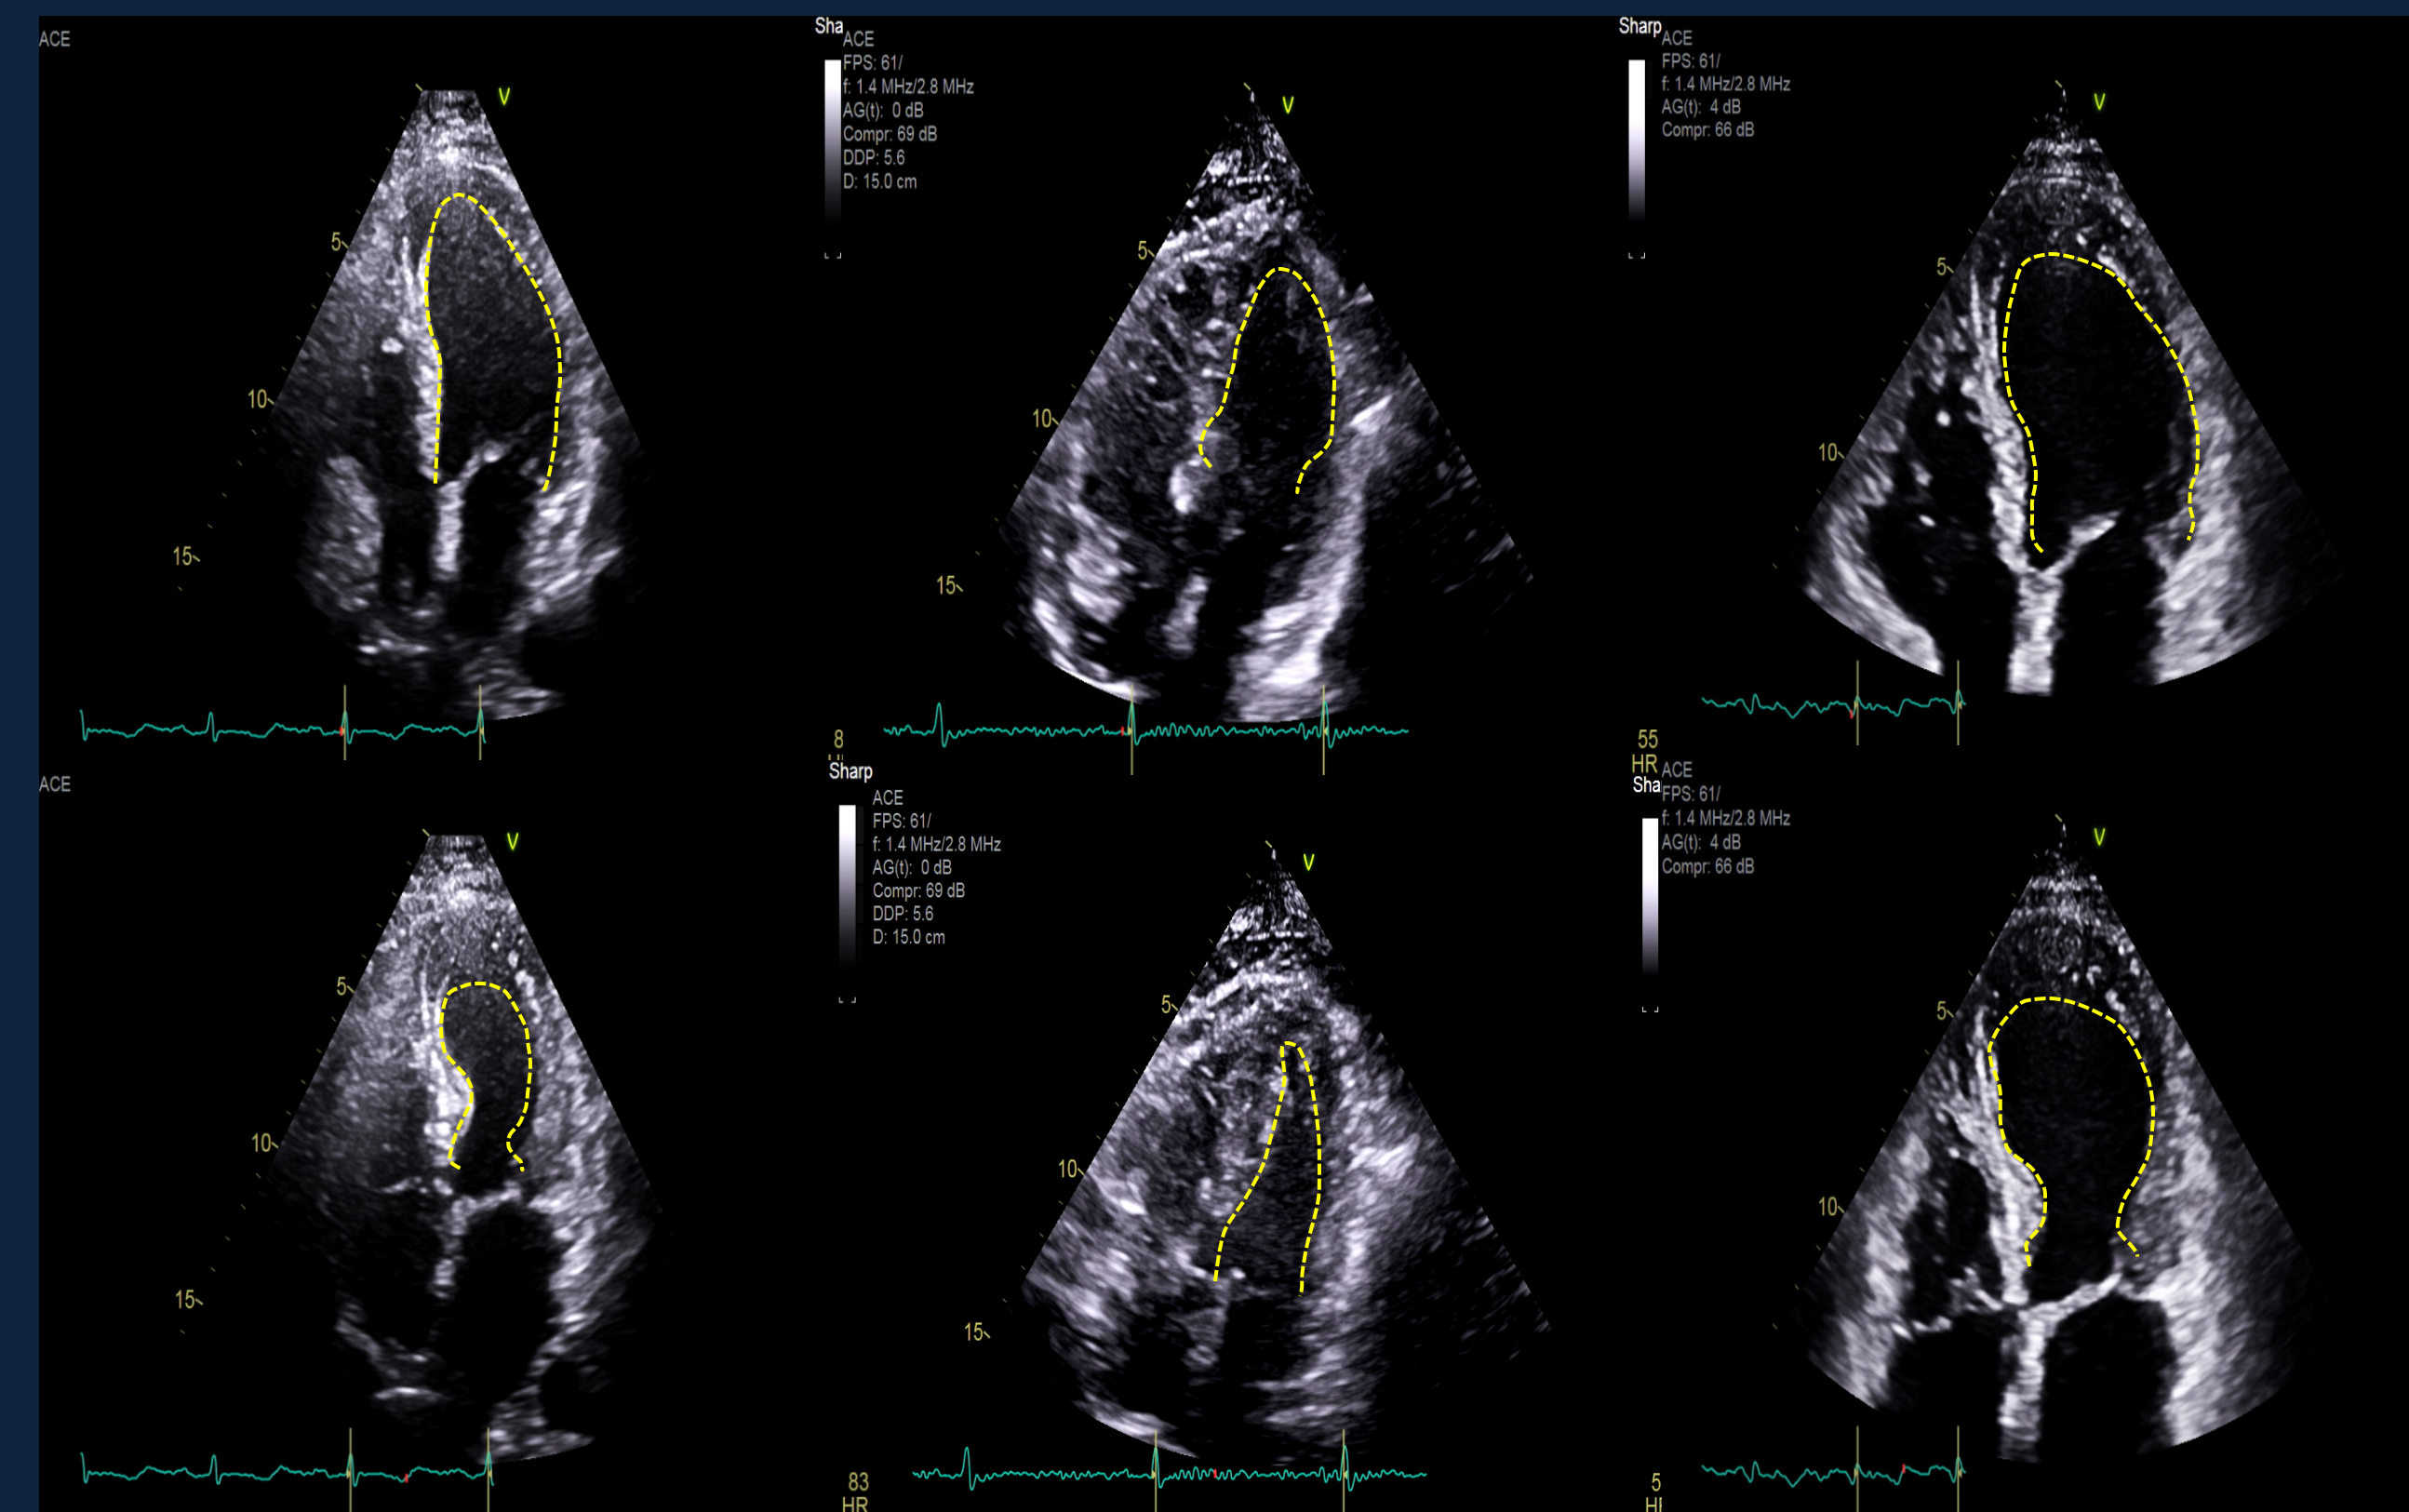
Transthoracic echocardiogram performed at initial presentation (A), at five month follow-up (B), and on readmission for recurrence of symptoms (C). Apical four-chamber in diastole (top row) and in systole (bottom row) demonstrating apical hypokinesis and basilar hyperkinesis on initial presentation (A) and again on readmission (C) with transient recovery and normalization of LV function between the hospitalizations (B). Endomyocardial border is outlined (yellow line) to help visualize wall motion abnormality and LV function.
